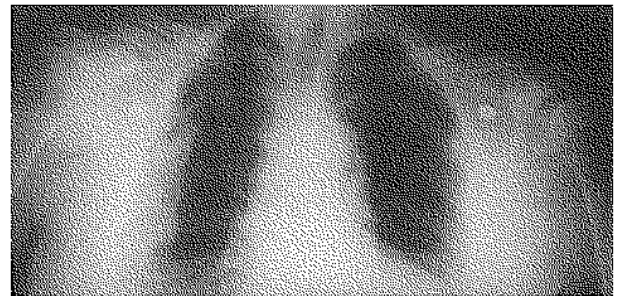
Radiograph of case 1 showing bilateral clavicle fractures.
